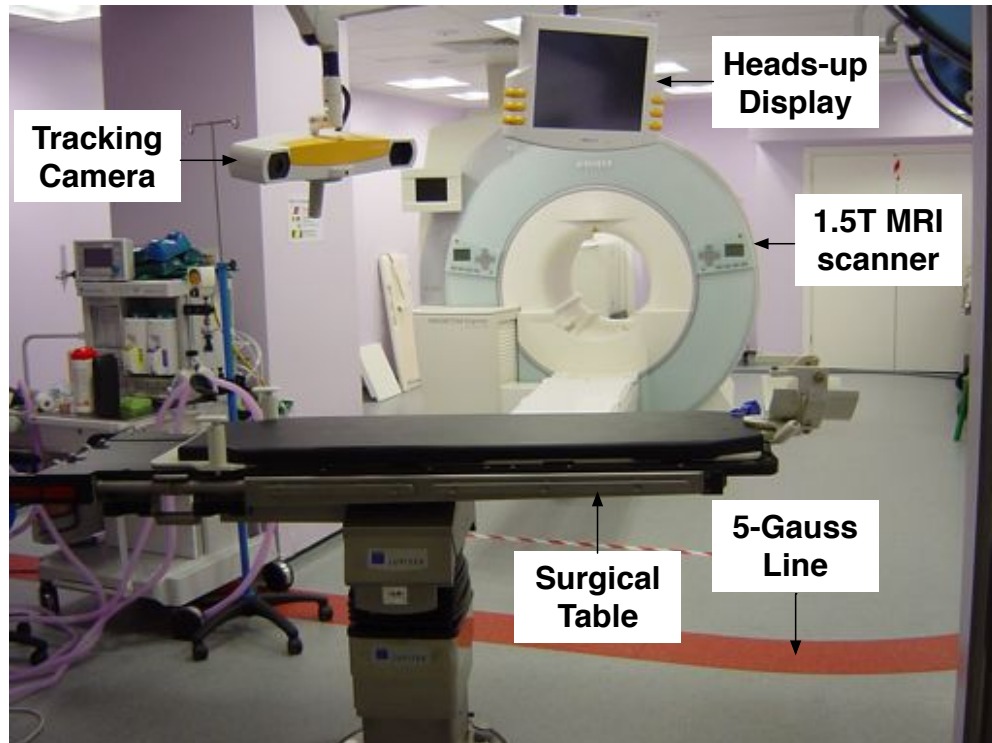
The interventional MRI surgical suite at the National Hospital for Neurology and Neurosurgery with a 1.5 tesla MR scanner and neuronavigation equipment. The surgical table interfaces with the scanner to enable the patient to be moved in and out of the scanner efficiently during surgery.
